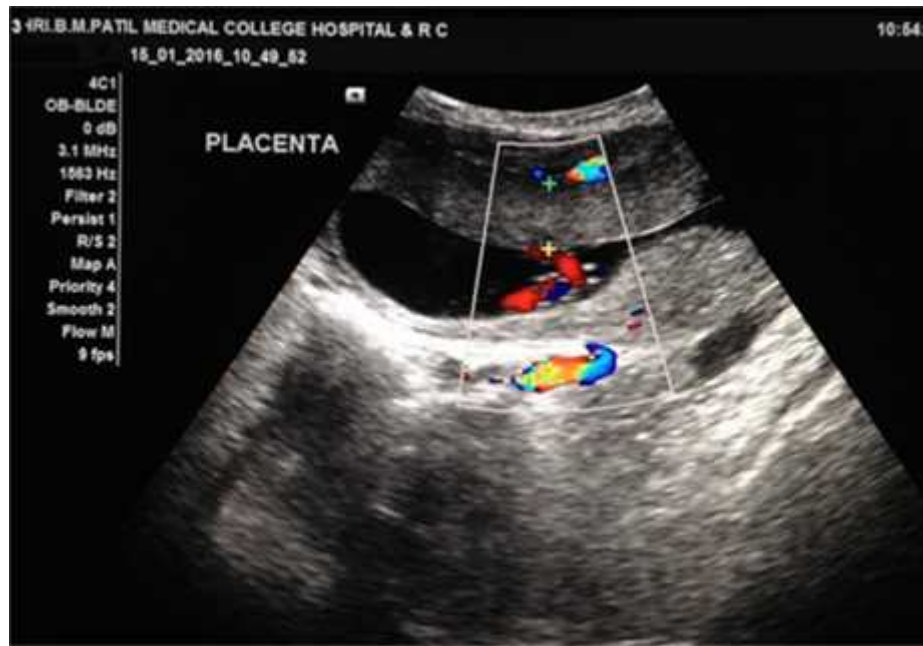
Ultrasonogram showing placenta before 20 weeks of gestation
